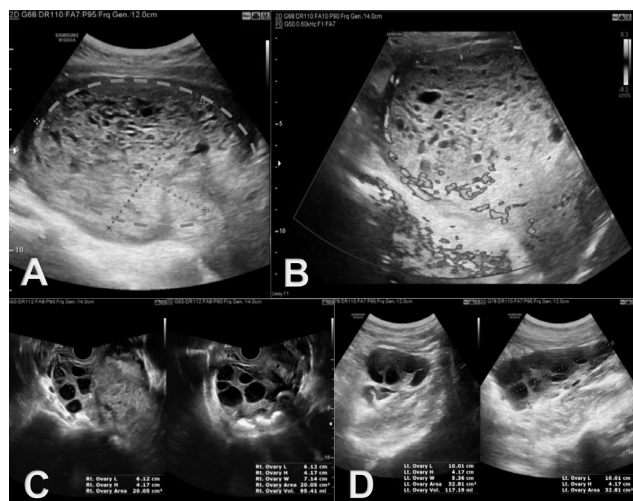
Transvaginal ultrasound of second molar pregnancy (2022)
